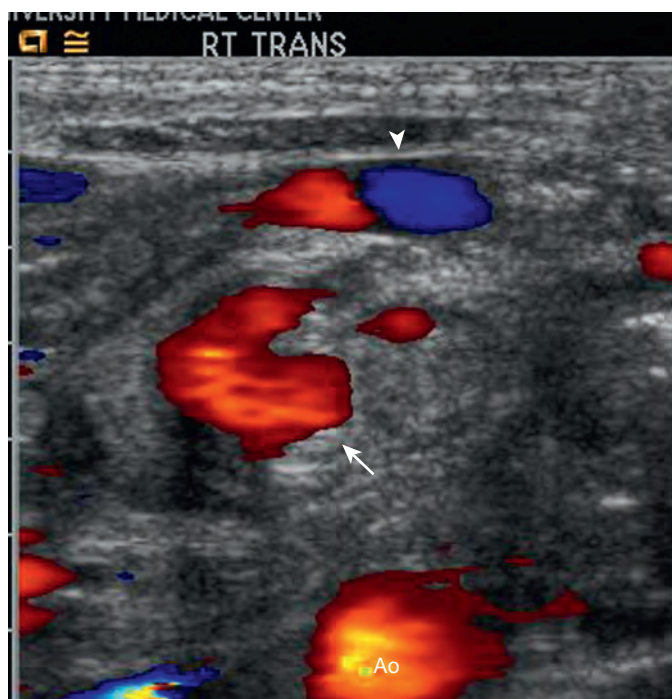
Malrotation with midgut volvulus. Transverse color Doppler sonogram of an epigastric mass shows the whirlpool sign consisting of the SMA (arrow) and SMV (arrowhead) twisted and draped clockwise around the mesentery, indicating midgut volvulus.
